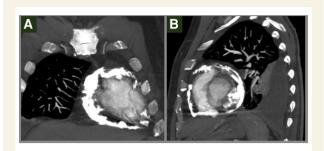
Computed tomography scan showing thickened pericardium (Arrows).
